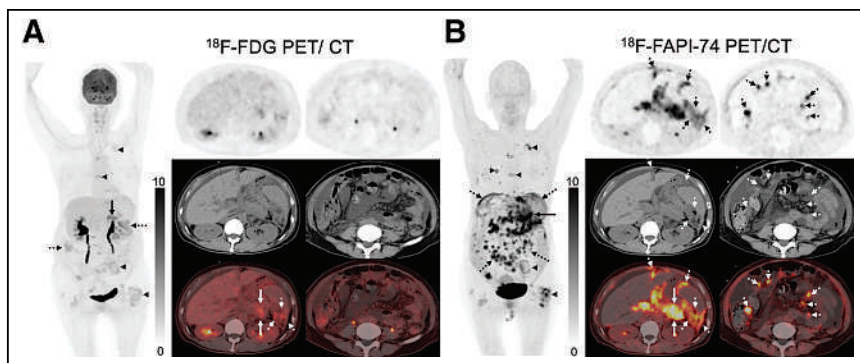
Representative case of widespread peritoneal metastatic pancreatic cancer (pancreatic ductal adenocarcinoma). (A) 55-y-old woman with biopsy-confirmed bone metastases underwent ^{18}F -FDG PET/CT for detection of primary tumor; low uptake is shown in primary lesion (solid arrows), peritoneal metastases (dotted arrows), and bone metastases (arrowheads). ^{18}F -FAPI-74 PET/CT shows intense uptake in these lesions. (B) In addition, ^{18}F -FAPI-74 PET/CT shows larger extent of peritoneal metastases than does ^{18}F -FDG.
